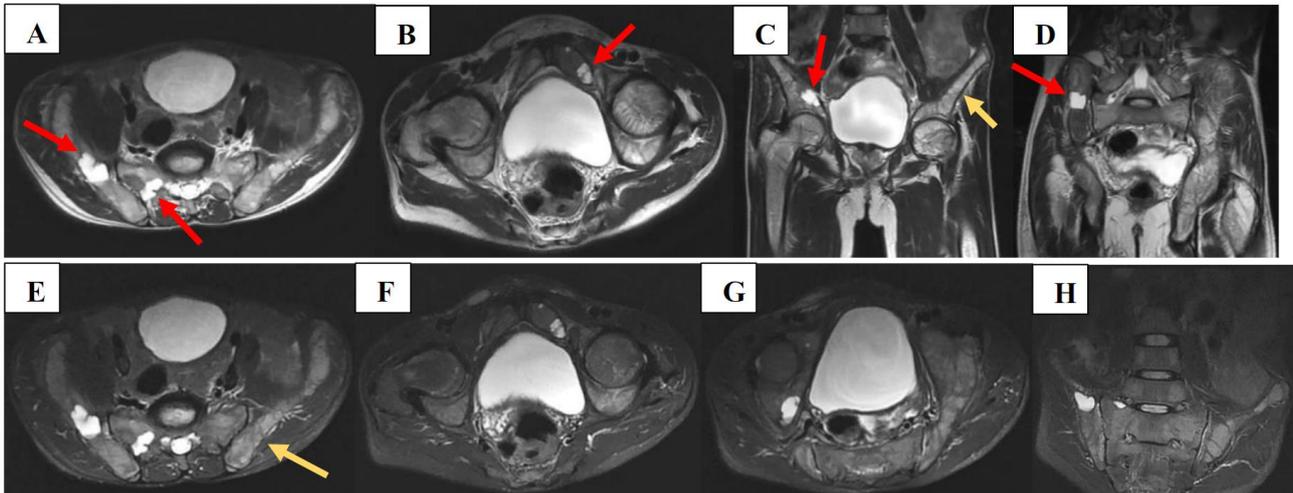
Axial and coronal MR images demonstrating diffuse bone signal anomaly of all pelvic bones with trabeculated appearance (yellow arrows) in T2 hypersignal (A, B, C, D) and STIR (E, F, G, H), combined with multiple well-defined iliac, pelvic and sacral cystic lesions (red arrows) that were hyperintense in T2-weighted images. Some had lobulated contours, compartmentalized and comprising hematic levels
